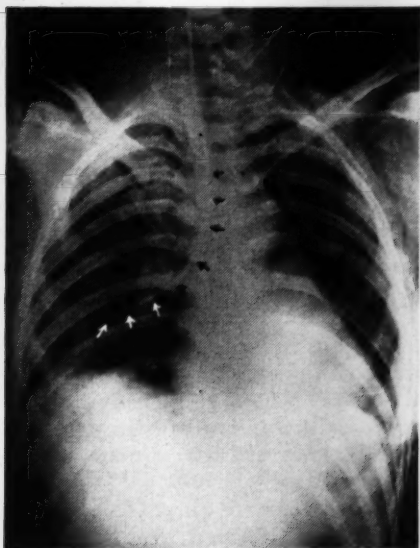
Roentgenogram of Thorax Showing Ureteral Catheter in place.
